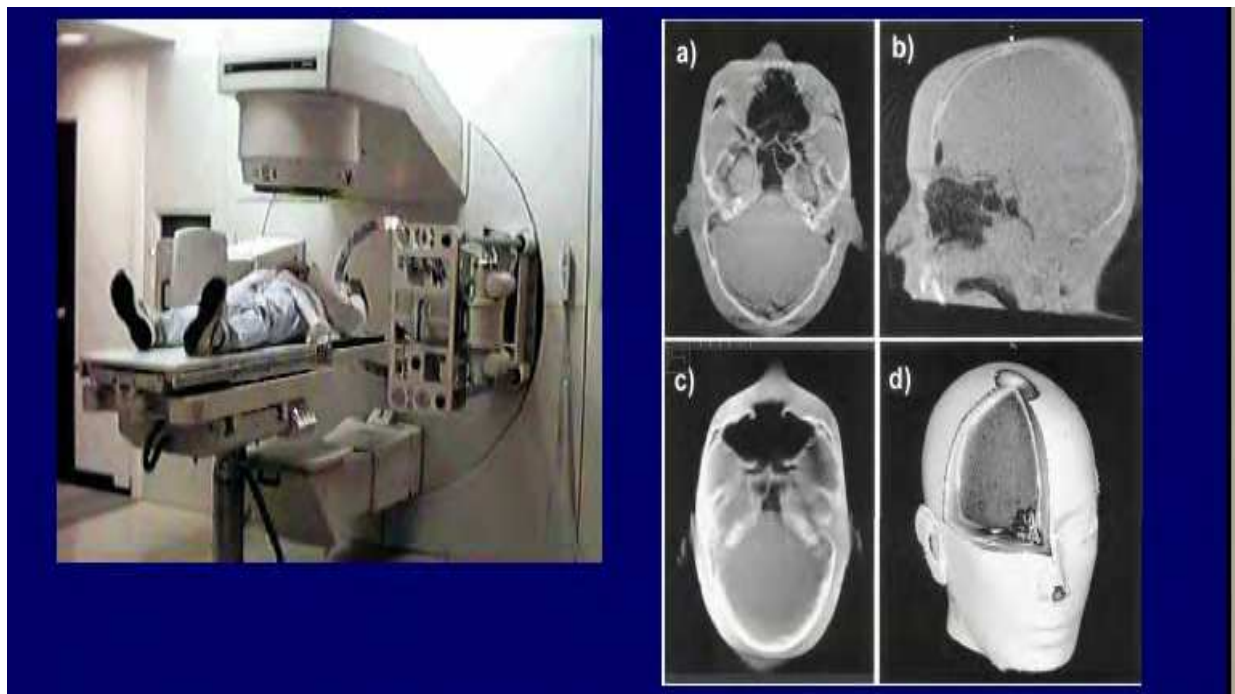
Cone beam imaging at Linac unit can provide daily set up
